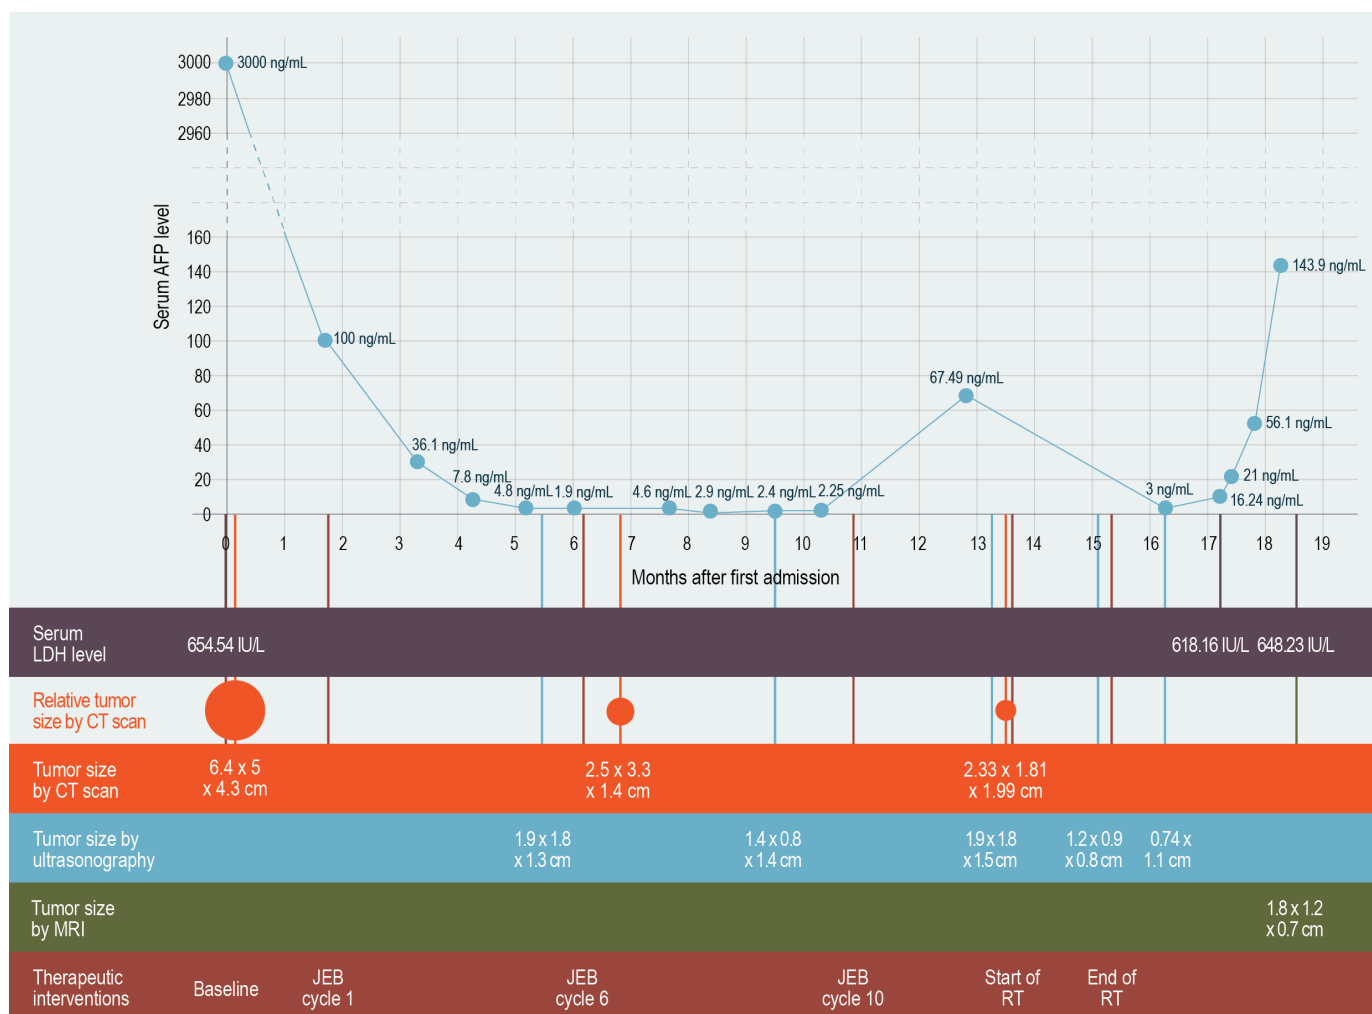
Chart showing temporal relationships of the therapeutic interventions, serum alpha-fetoprotein (AFP) levels, serum lactate dehydrogenase (LDH) levels, and the patient's tumor sizes by computed tomography (CT) scan, ultrasonography, and magnetic resonance imaging (MRI).
